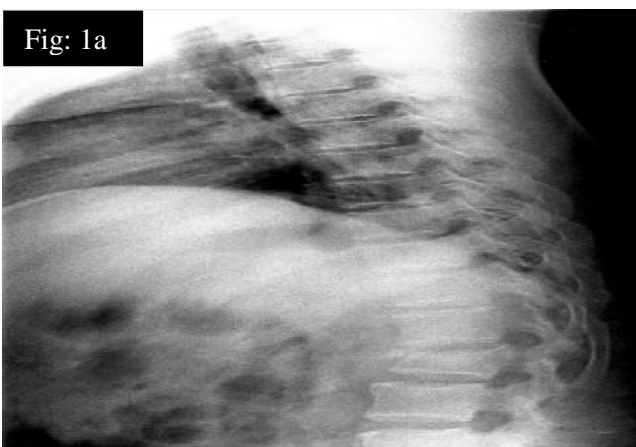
Plain radiographs showing L1 vertebral burst fracture
